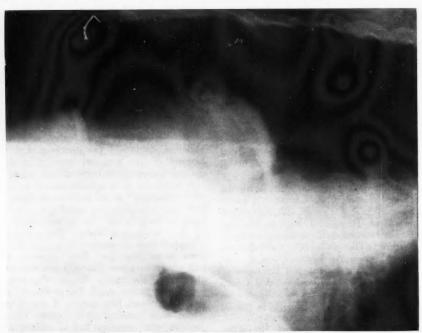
Radiograph of Case 2 in lateral decubitus showing a large amount of free air.
